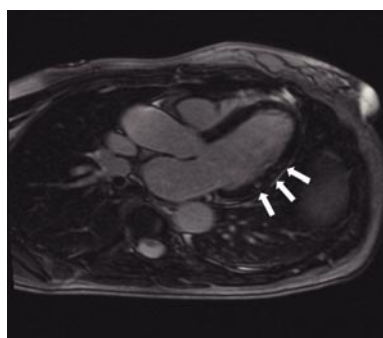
Signs of myocarditis (arrows) on cardiac magnetic resonance imaging
